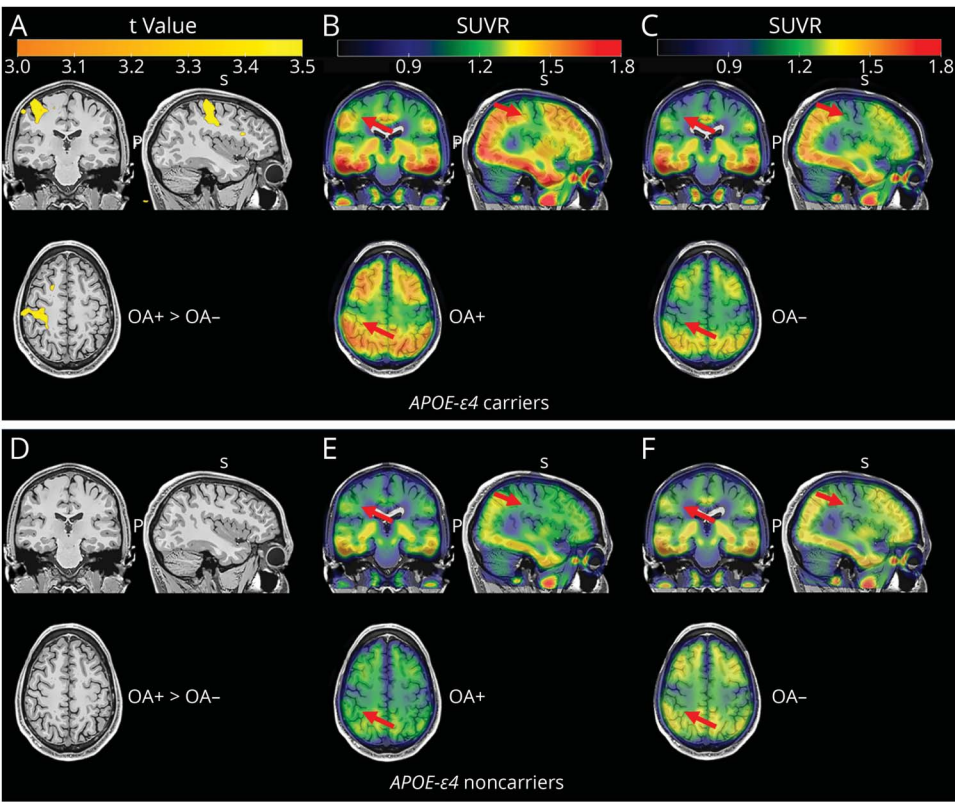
Abbreviations: Aβ = β-amyloid; APOE4+ = individuals with APOE-ε4 allele; β_{std} = standardized β value; CI = cognitively impaired; FBP = ¹⁸F-florbetapir; FTP = ¹⁸F-flortaucipir; OA = osteoarthritis; OA+ = individual with osteoarthritis; p_{adj} = adjusted p value, which was obtained by using the Benjamini-Hochberg method multiple comparison corrections; SUVR = standardized uptake value ratio.
